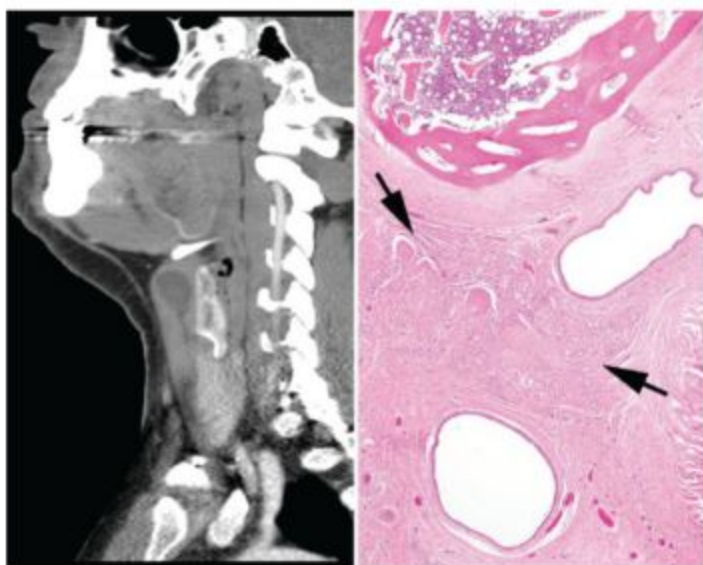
Left: A sagittal computed tomography scan shows a cyst below the hyoid bone in the midline neck, with a duct continuing inferiorly. Right: The hyoid bone is noted in proximity to epithelial lined cystic spaces. Thyroid follicles are noted (arrows) in the stroma.
